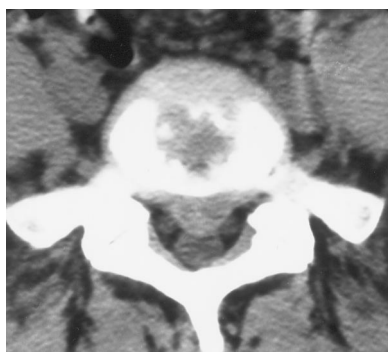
Axial CT section through L5-S1 shows rather large posterior central displacement of disk material, with slight dural sac compression. According to the definition, this displacement should qualify as a protrusion. However many observers will be inclined to use the word *extrusion* because of its large size.
